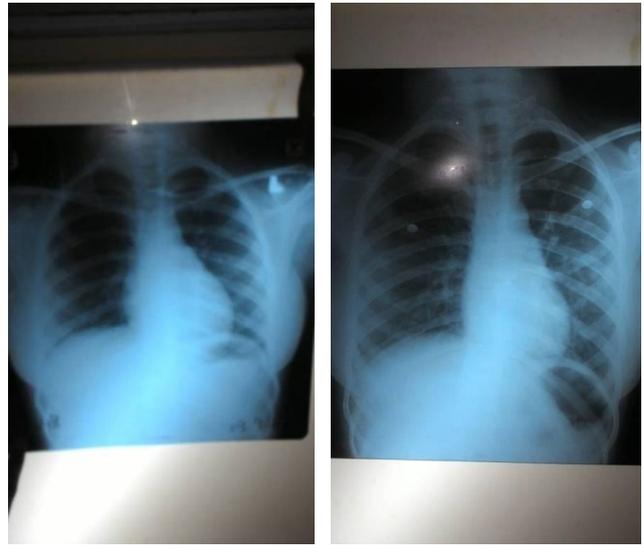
(a) and (b) Chest X-ray
